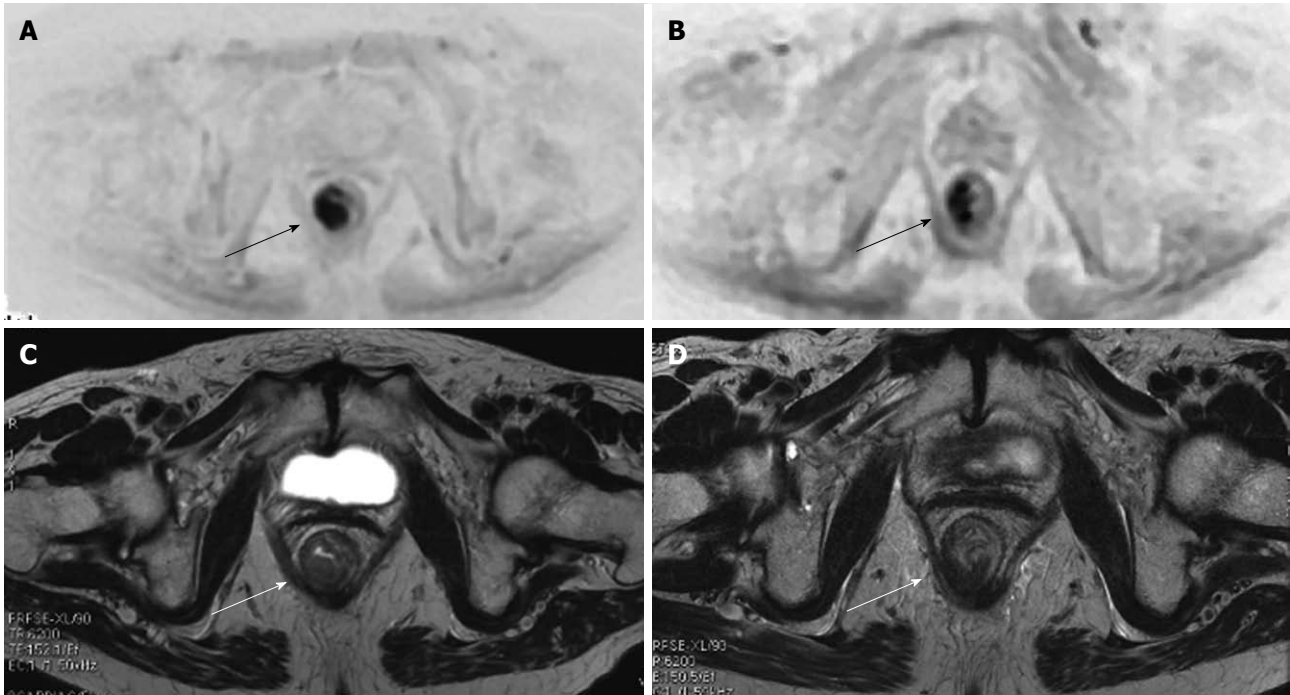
Diffuse weighted imaging and cancer (arrows) of the lower rectum. At initial MR staging T3N1. After neoadjuvant therapy, MR restage was T3N0. At pathology: T3N1 (only one small metastatic mesorectal lymph node). Diffusion weighted imaging (DWI) (A) and axial T2w (B) images show the tumor (arrows) before chemoradiotherapy. The DWI image allows for better recognition of the lesion. DWI (C) and axial T2w (D) images after chemoradiotherapy show a reduction in the dimensions of the lesion (arrows).
